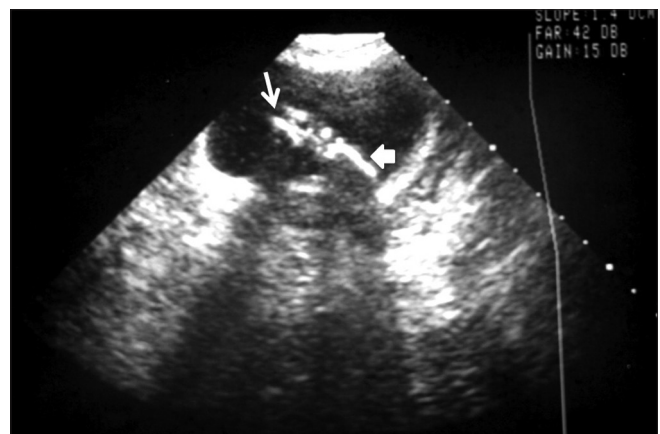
Ultrasound showing multiple calculi (arrow) and a linear echogenic focus (arrowhead) suggestive of intrauterine device within the urinary bladder
